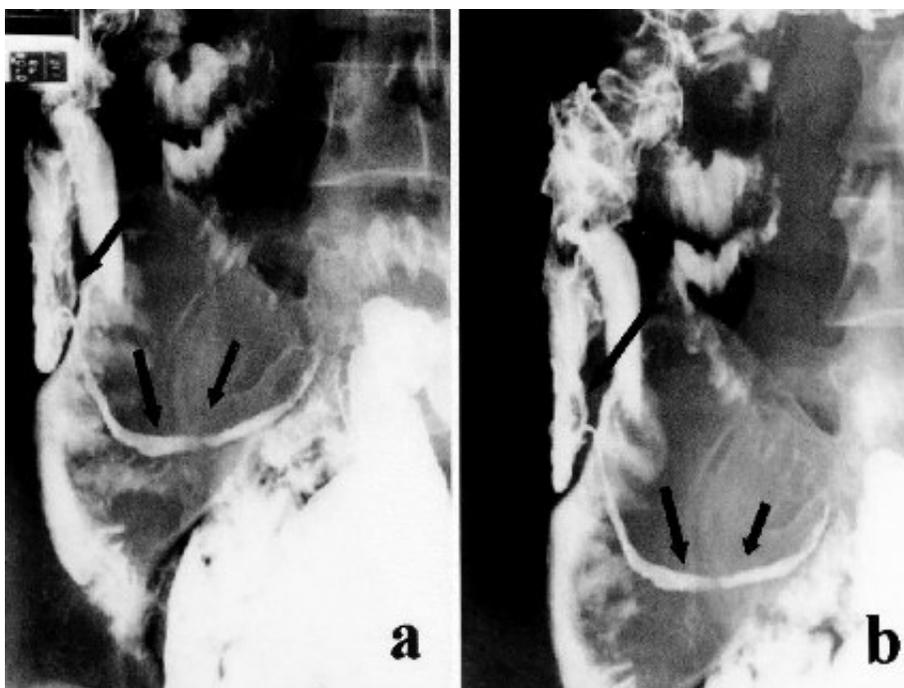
a e b) Abdominal barium x-rays (8/7/1998). Prolonged spasm of the last tract. The filling defect between caecum and ascending colon is reduced.
